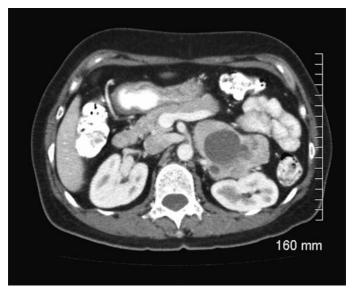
Computed tomography scan of a large left pheochromocytoma; note the areas of necrosis with cystic degeneration. (Courtesy of Darren P. Lum, MD.)
